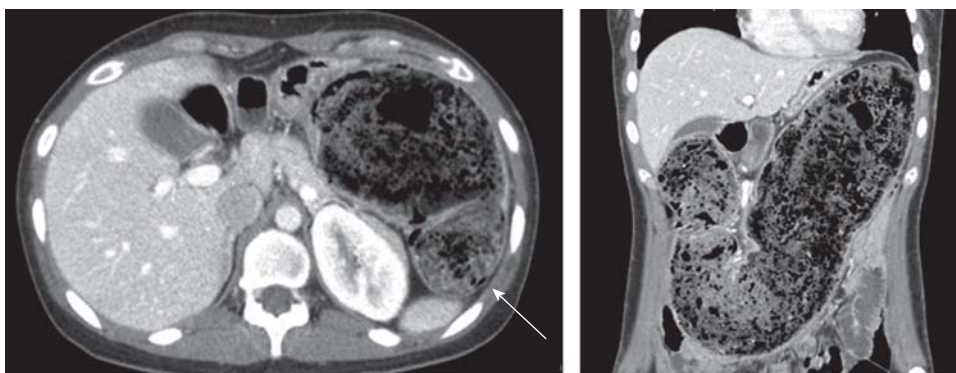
Ogilvie syndrome in a 31-year-old woman. Axial (left panel) and coronal (right panel) contrast-enhanced computed tomography images demonstrate a markedly distended transverse colon with large amount of fecal material. The arrow in the left panel points at the transitional zone (splenic flexure) that is devoid of any obstructive lesions. (Used, with permission, from Choi et al.⁸⁹)
